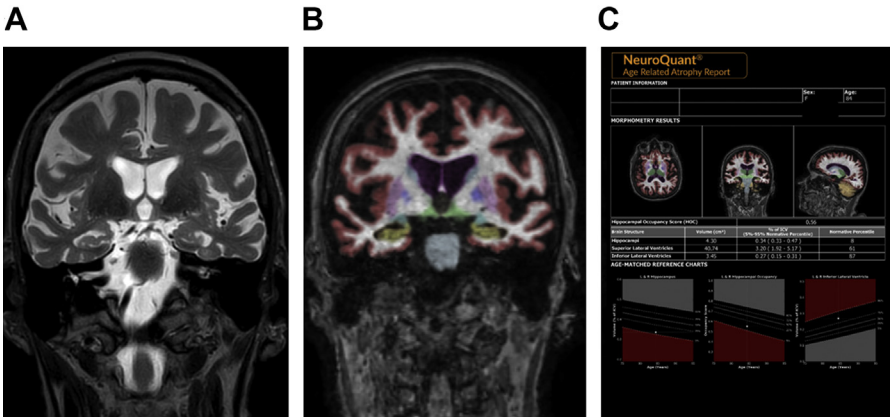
Coronal T2-weighted image (A) shows diffuse enlargement of the frontal and temporal sulci, as well as the body and temporal horns of the lateral ventricles. (B) shows the color segmentation of the 3D T1 image in coronal plane, at the same slice position as (A). The hippocampi are marked in yellow. The age-related atrophy report (C) provides the absolute combined volumes of the hippocampi and lateral ventricles, their proportion in the intracranial volume, and the normative percentile compared with a database of healthy age-matched controls. At the bottom of the report, these values are visualized.
